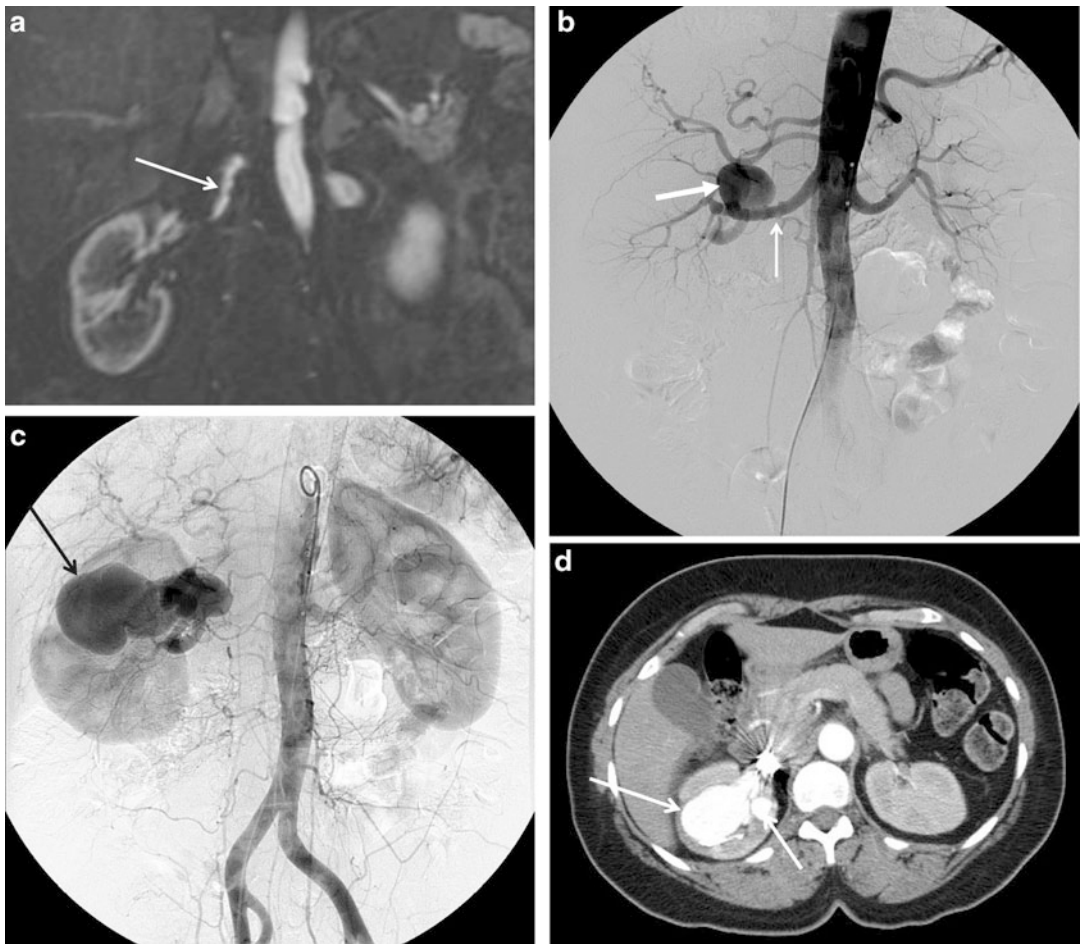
CTA and MRA of fibromuscular dysplasia. (a) The T1-weighted, fat-suppressed postcontrast MRA image shows beaded irregularity of the right renal artery (*arrow*). (b) The image from a catheter-directed arteriogram also reveals the beaded appearance of the right renal artery (*arrow*) and an aneurysm arising from the right renal
